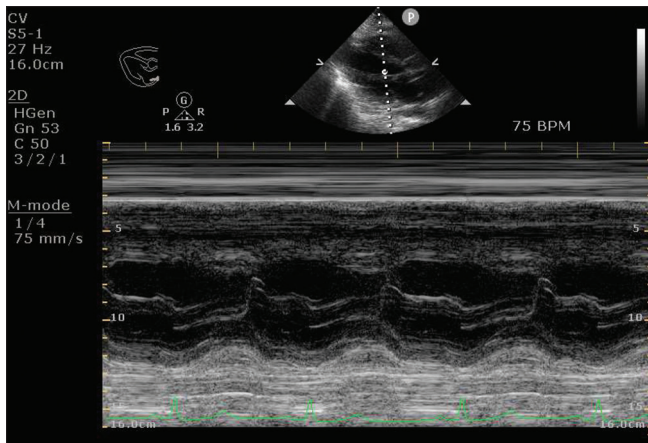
Point-of-care ultrasound revealed EPSS < 7 mm, suggesting preserved left ventricular myocardial contractility
